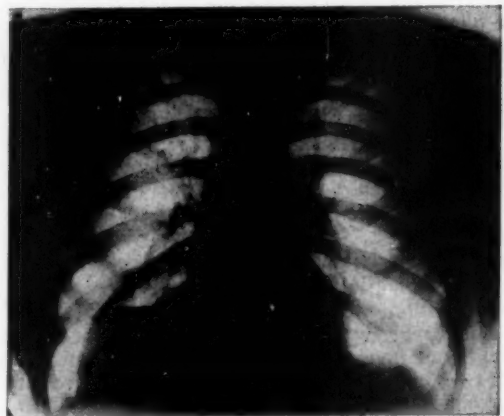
Radiograph made on second examination, showing a fluid level in the area of opacity shown in the right chest in Figure 1.
